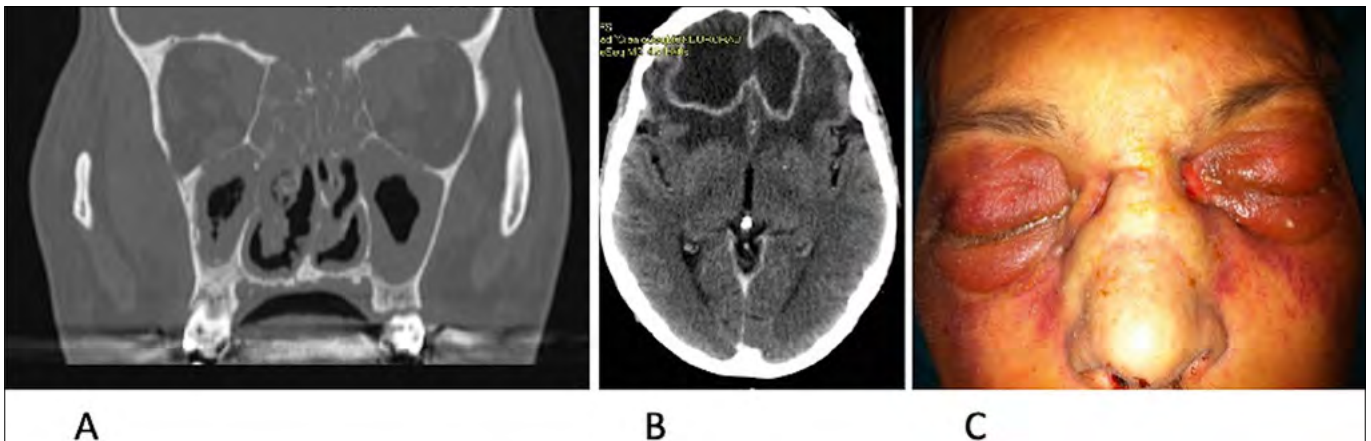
(A) CT with mucormycosis of frontal, ethmoidal and maxillary sinuses; (B) CT with huge frontal abscess; (C) orbital cellulitis.
